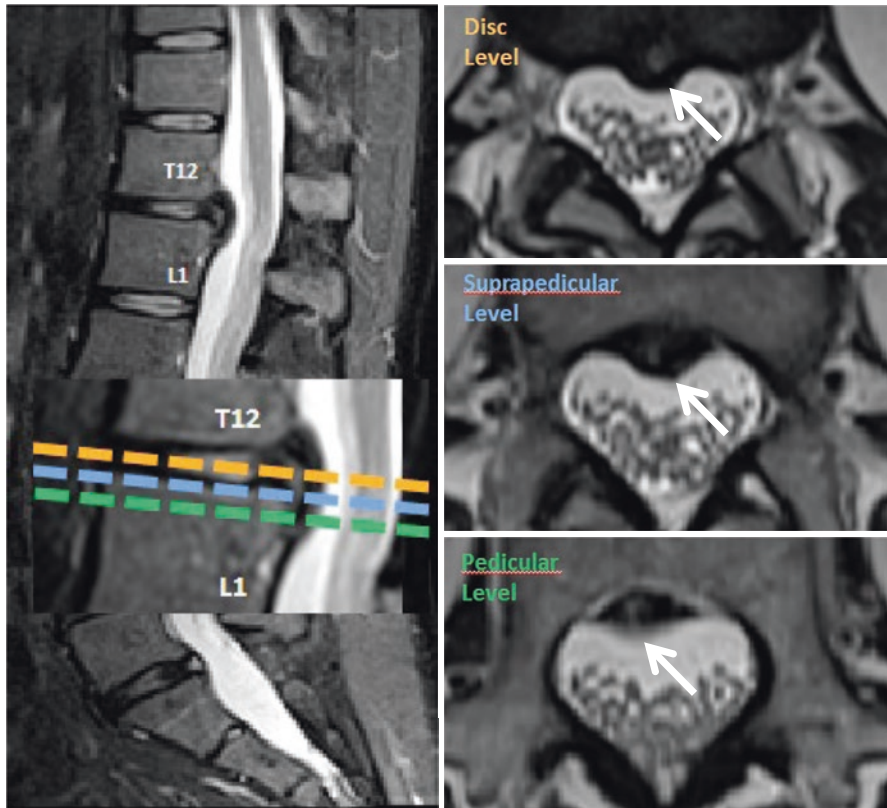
Sagittal and sequential axial T2W MR images show a disc extrusion (arrows) with caudal migration (from disc (Orange) to Pedicular (Green) level)
